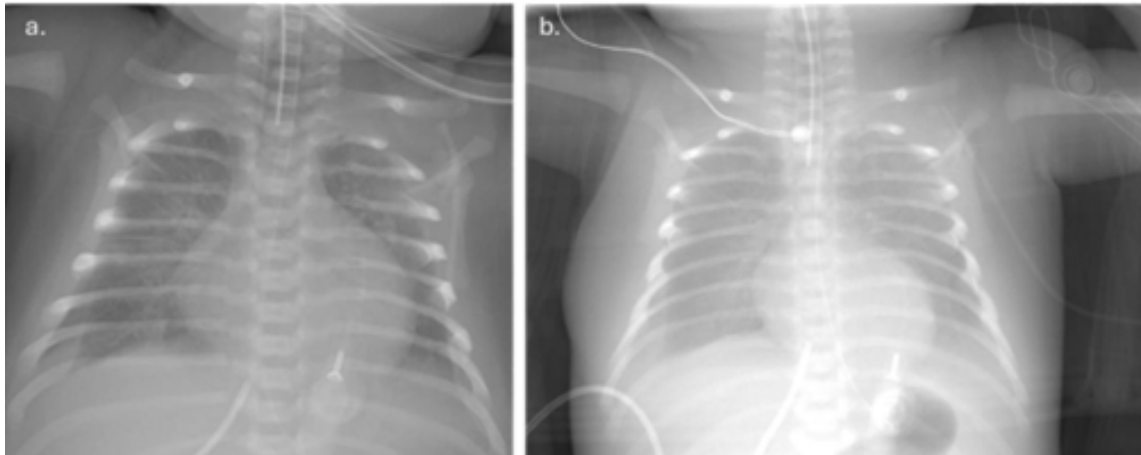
X-Ray images. (a) X-ray recorded just after positioning of pericardial drainage. Cardiomegaly is shown; (b) X-ray recorded after complete drainage of chylous pericardial liquid.
